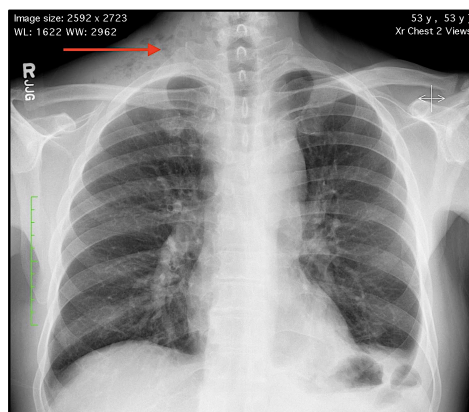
Chest x-ray, A/P view
